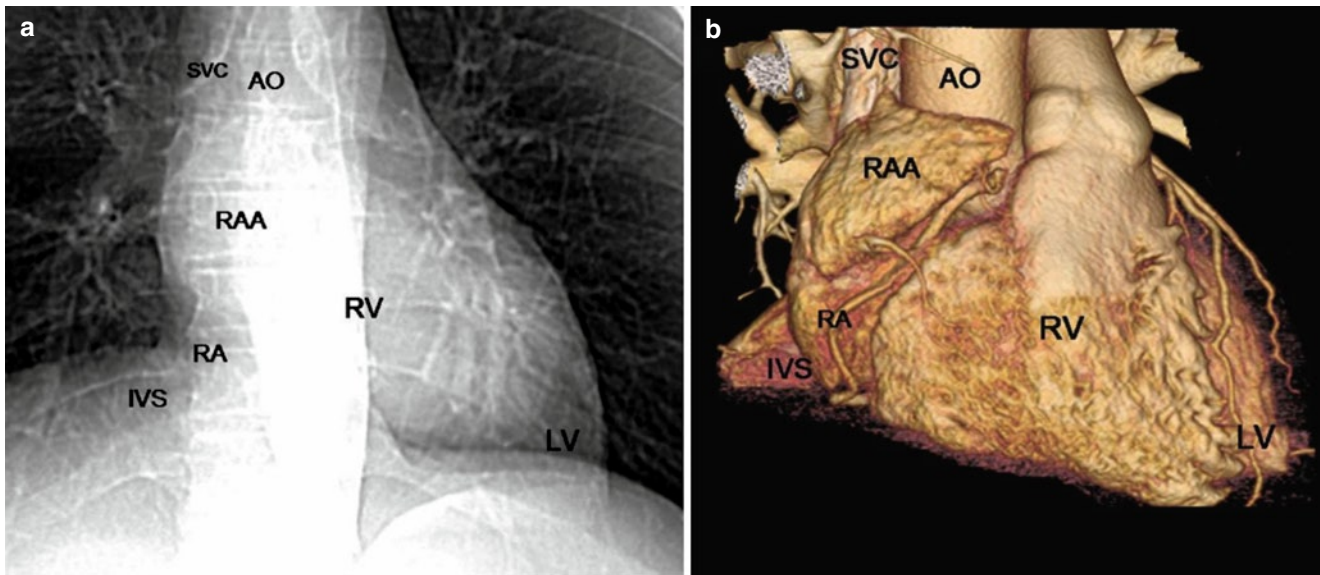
(a) Fluoroscopic image in antero-posterior projection of the heart and (b) the corresponding 3D CT volume rendering. *IVS* inferior vena cava, *SVC* superior vena cava, *RA* Right atrium, *RAA* right atrial appendage, *RV* right ventricle, *LV* left ventricle, *Ao* Aorta
